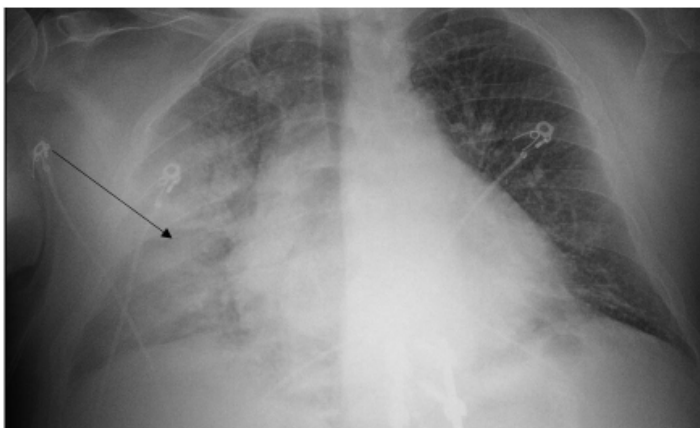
Initial emergency department chest radiograph with evidence of acute right-sided “flash” pulmonary edema (arrow).
